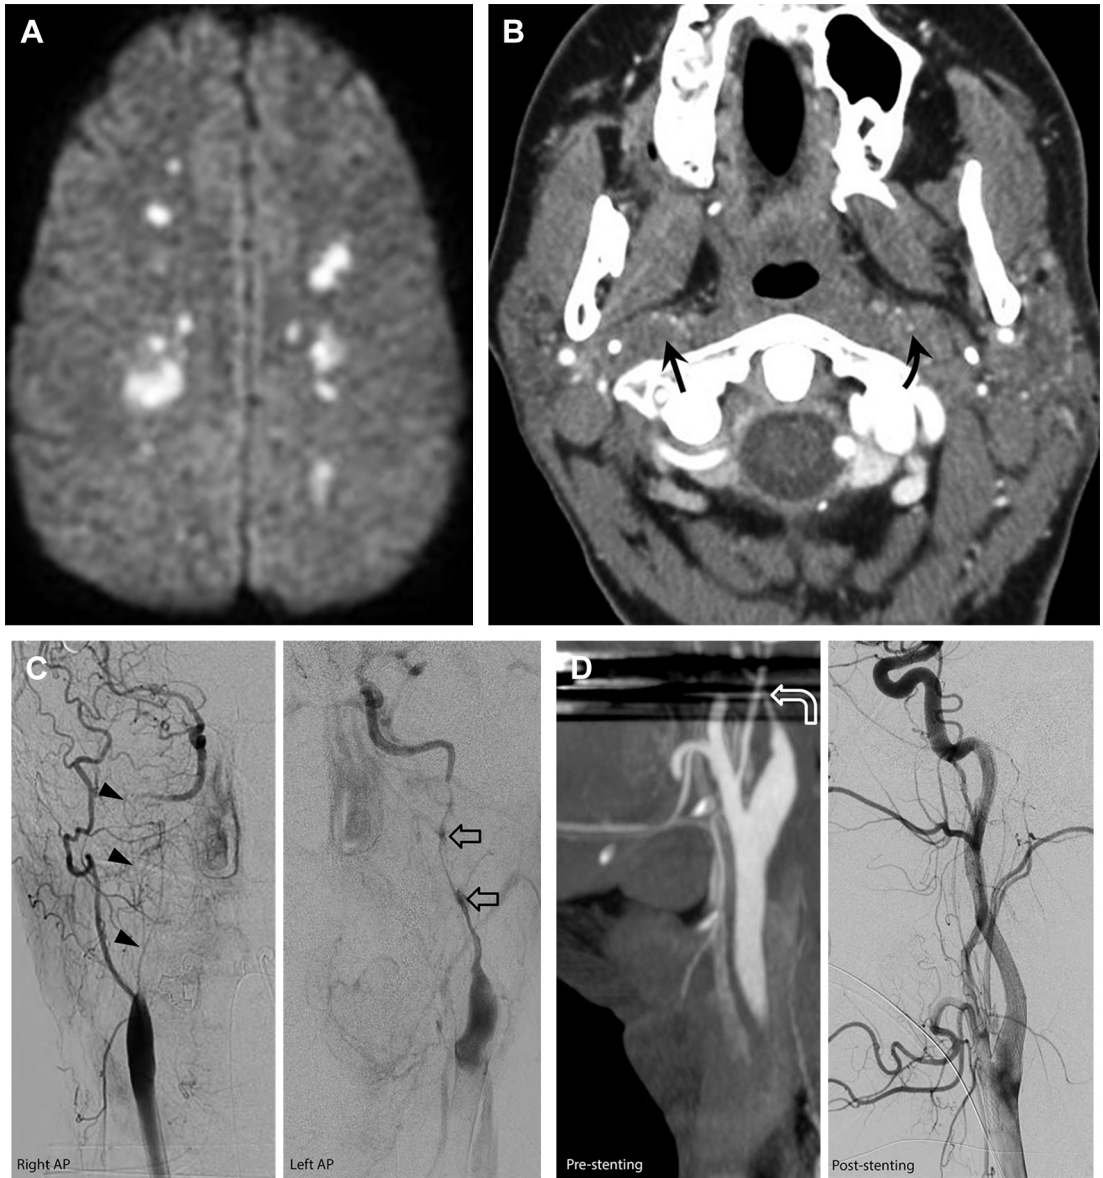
Bilateral terminal zone infarcts due to ICA dissections with “string” signs. (A) Axial diffusion-weighted image demonstrates bilateral acute terminal zone infarcts compatible with hypoperfusion, raising the strong possibility of bilateral ICA injury. (B) Axial CTA image confirms a left carotid string sign (*curved arrow*) and possible right carotid occlusion (*arrow*). (C) Bilateral carotid angiograms demonstrate severe bilateral tapered ICA stenoses (Denver grade 2) due to ICA dissections. There is severe right ICA luminal compromise (string sign) (*arrowheads*) and an irregular left ICA stenosis with several focal dilatations (string-and-pearl sign) (*open arrows*). (D) Prestenting and poststenting images of the left ICA reveal marked improvement of the severe left ICA stenosis (*curved open arrow*).
